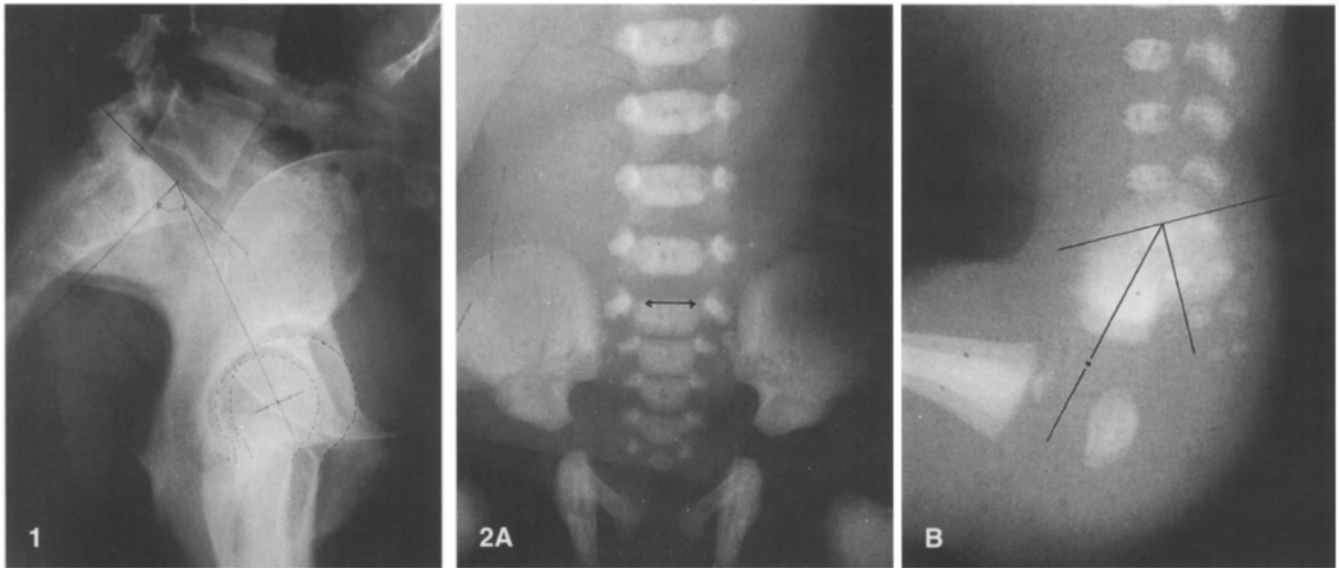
The incidence angle is formed by a line perpendicular to the upper sacral endplate, beginning at its centre and the line joining this point and the centre of the line uniting the middle of the femoral heads, on lateral radiographs
